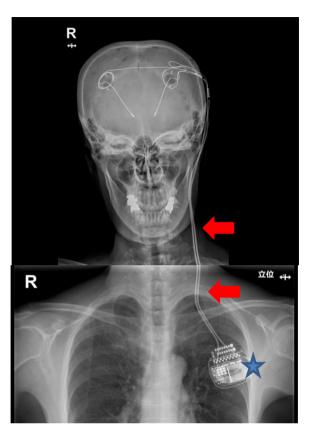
Radiograph of the head and chest. The device had been implanted in the chest (star) and connected to an extension device (arrowhead) with leads, which are implanted in the brain.
